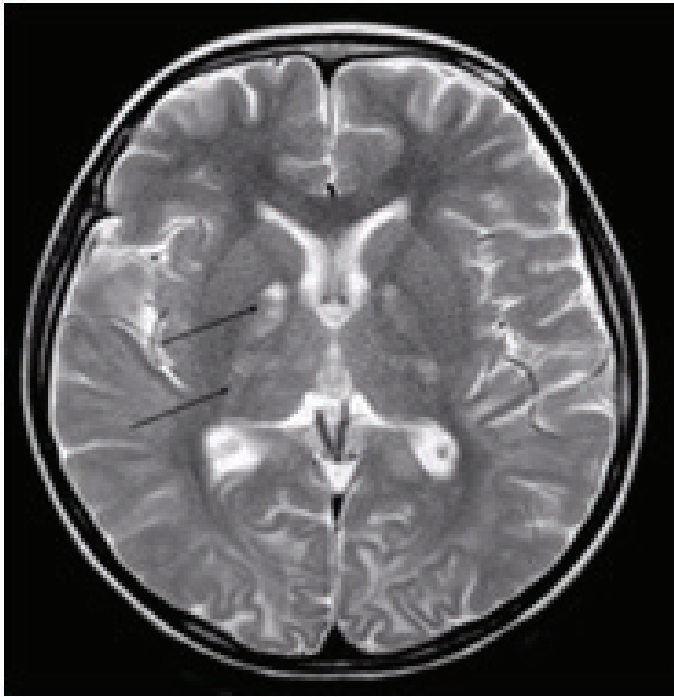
Axial T2-weighted image demonstrating hyperintensities in the pale globes and internal capsules.
